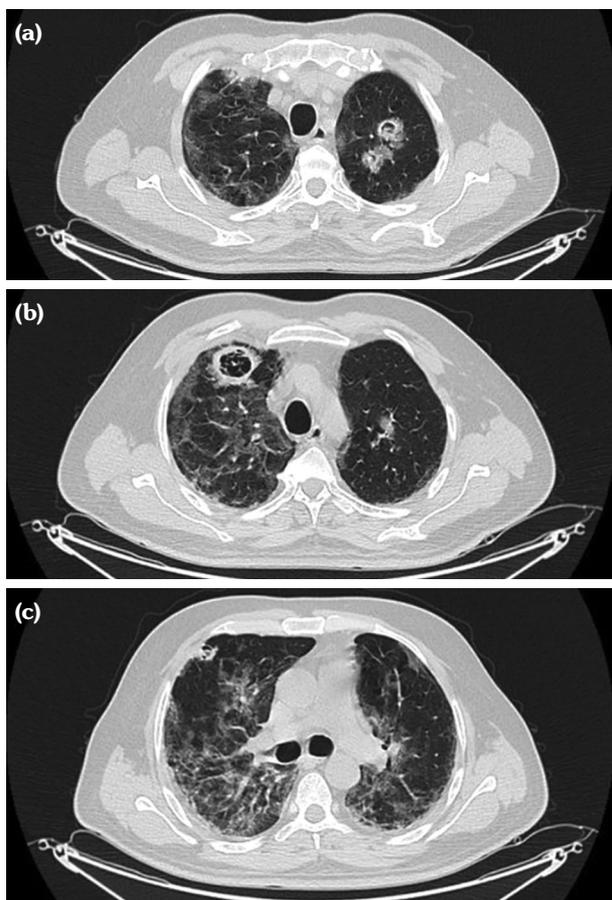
CT images obtained on August 28, 2020. (a) A CT image showing two cavitory lesions in upper lobe of left lungs. (b) A 27 x 25-mm cavitory lesion with an 8-mm wall thickness in right upper lobe. (c) Small cavitory lesion in upper lobe of right lung adjacent to pleura. CT: Computed tomography.
